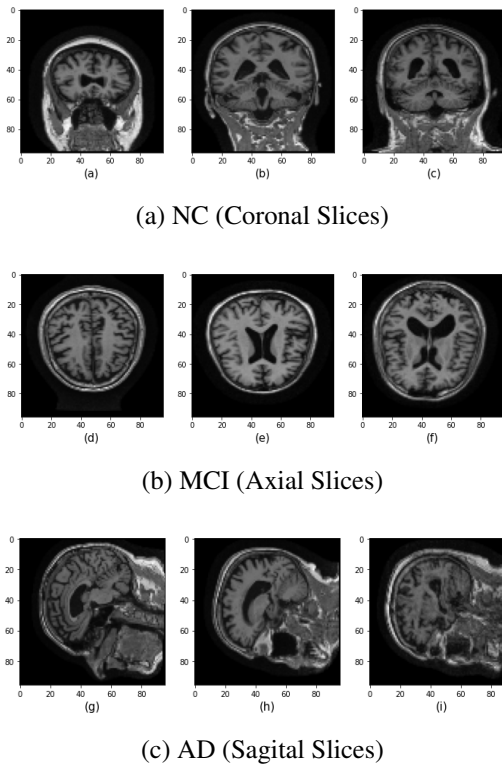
MRI scans depicted various stages of Alzheimer's disease.
